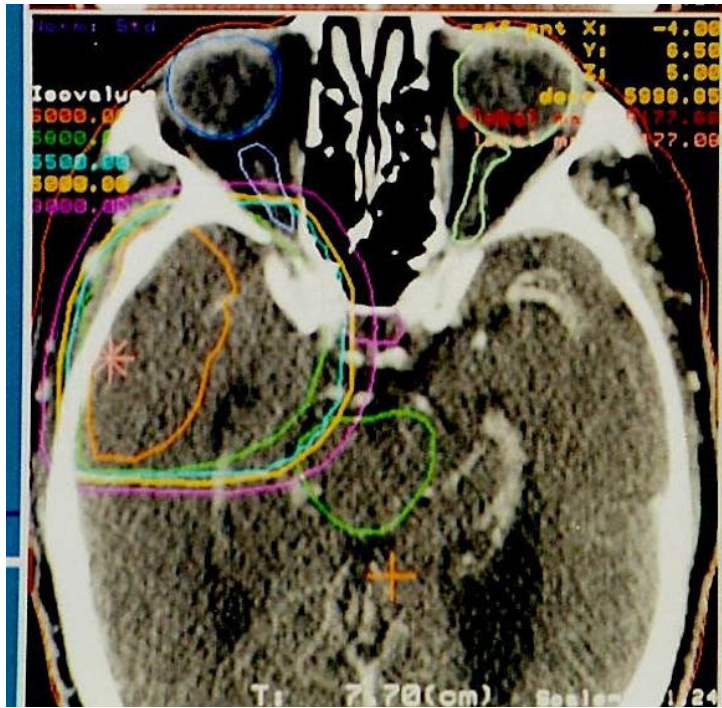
Axial CT slice at the level of the right optic nerve with the pituitary, globes, optic nerves and brain stem delineated and isodose contours superimposed. Show at least the 6420, 6000, 5800, 5500, 5000, and 3000 cGy contours.
